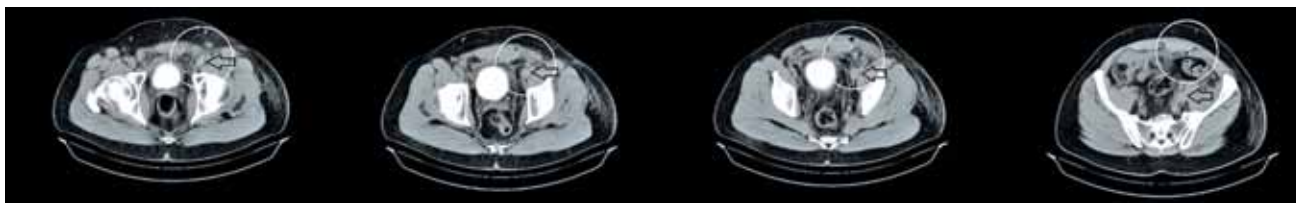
Consecutive slices of the computed tomography angiography showing the course of the EKOS EndoWave catheter during the extravasation from the iliac vein. Note the arrows are pointing at the iliac vein. The circles are showing the route the catheter tip took while passing out of the iliac vein into the abdominal wall.
